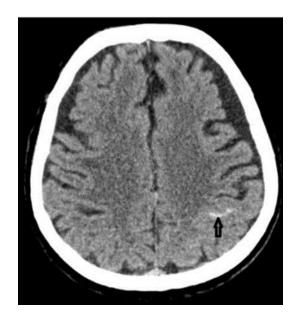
CT scan of the head (axial scan): acute traumatic subarachnoid hemorrhage, left subdural hygroma Slika 1. CT glave (aksijalna snimka): akutno traumatsko subarahnoidno krvarenje, lijevi subduralni higrom
